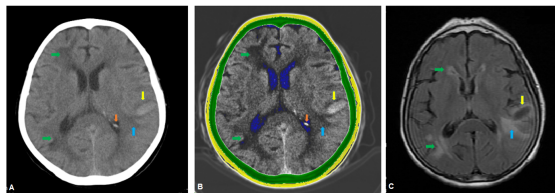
A hemorrhagic lesion in left temporal lobe (yellow arrow) associated with adjacent edema (blue arrow) and periventricular edema (green arrows) due to microvascular changes and choroid plexus calcification in the left side (orange arrow). (A) unprocessed grayscale CT image; (B) processed color CT image; (C) corresponding T2-FLAIR MRI scan.
